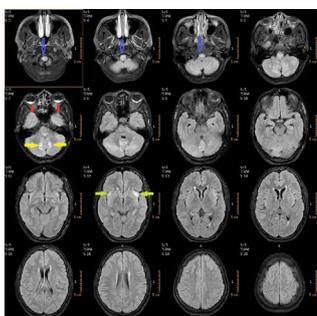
PRES SCI – Axial FLAIR images in pediatric patient with renovascular accelerated hypertension showing hyperintense signal in brainstem and cervical spinal cord (blue arrow), cerebellar hemisphere (yellow arrow) and bilateral insular cortex. Sub-hyloid hemorrhage is also seen in both eye globes (red arrow).
